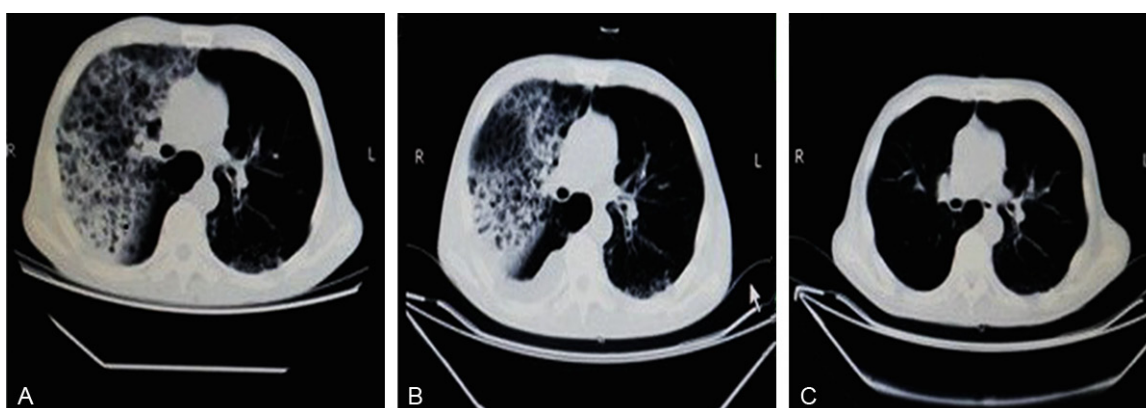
Chest computed tomographies (CT). A: Upon first admission, diffuse infiltrating lesions were evident in right lobe; B: one week after ceftriaxon was initiated, a slight decrease of the lesions can be observed; C: Chest computed tomographies (CT) showed hydropneumothorax after lung biopsy in second admission.
